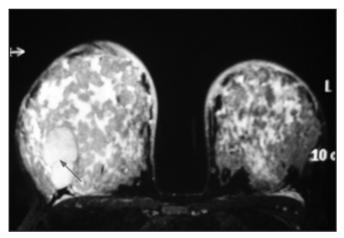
MRI Of The Breasts: T2 Weighted fat saturation showing a bright lesion measuring 6 cm x 4 cm x 3.5cm in the right breast with thin septation (arrow) within. This lesion showed Type 1 kinetic enhancement curve suggestive of a fibroadenoma.
